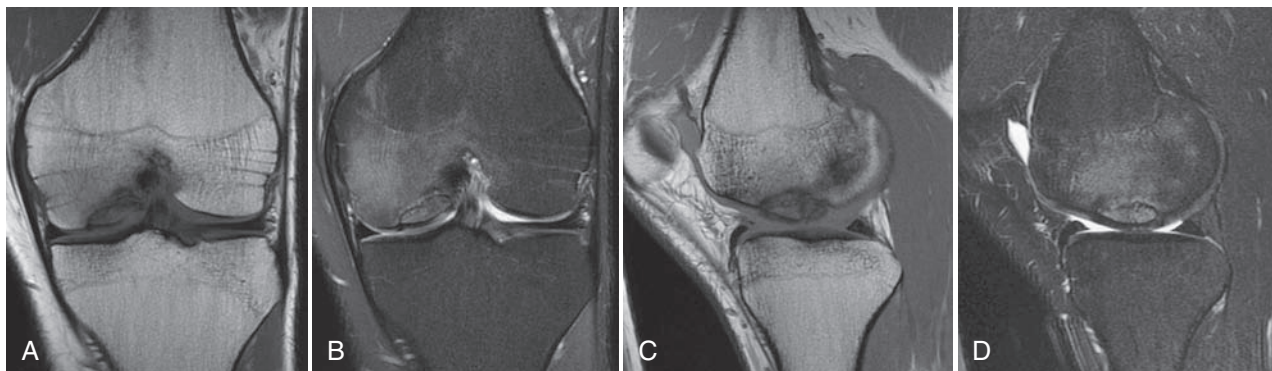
Magnetic resonance imaging (MRI) of an osteochondritis dissecans (OCD) lesion at the lateral aspect of the medial femoral condyle. Anteroposterior T1-weighted (A) and T2-weighted (B) views. Sagittal T1-weighted (C) and T2-weighted (D) views.
